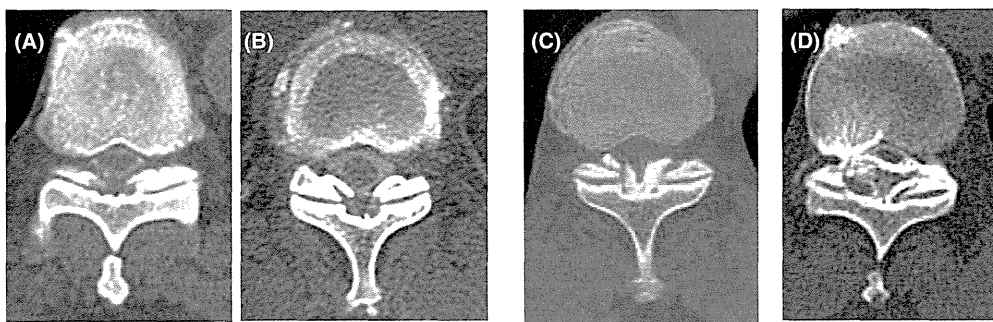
The CT axial classification of OLF with scans obtained at the middle of the facet joint. (A) Lateral type. The ossified ligamentum flavum is located only in the capsular portion of the ligamentum flavum, which can be detected at the lateral edge of the spinal canal. (B) Extended and enlarged type. The ossified ligamentum flavum is located at the surface of the ligamentum flavum and protrudes into the spinal canal. (C) Fused type. Bilateral ossified ligamentum flavum fused at the middle of the ossified ligamentum flavum. (D) Tuberos type. Fused ossified ligamentum flavum formed a tuberos mass at the middle of the spinal canal. OLF indicates ossification of the ligamentum flavum; CT, computed tomographic.
